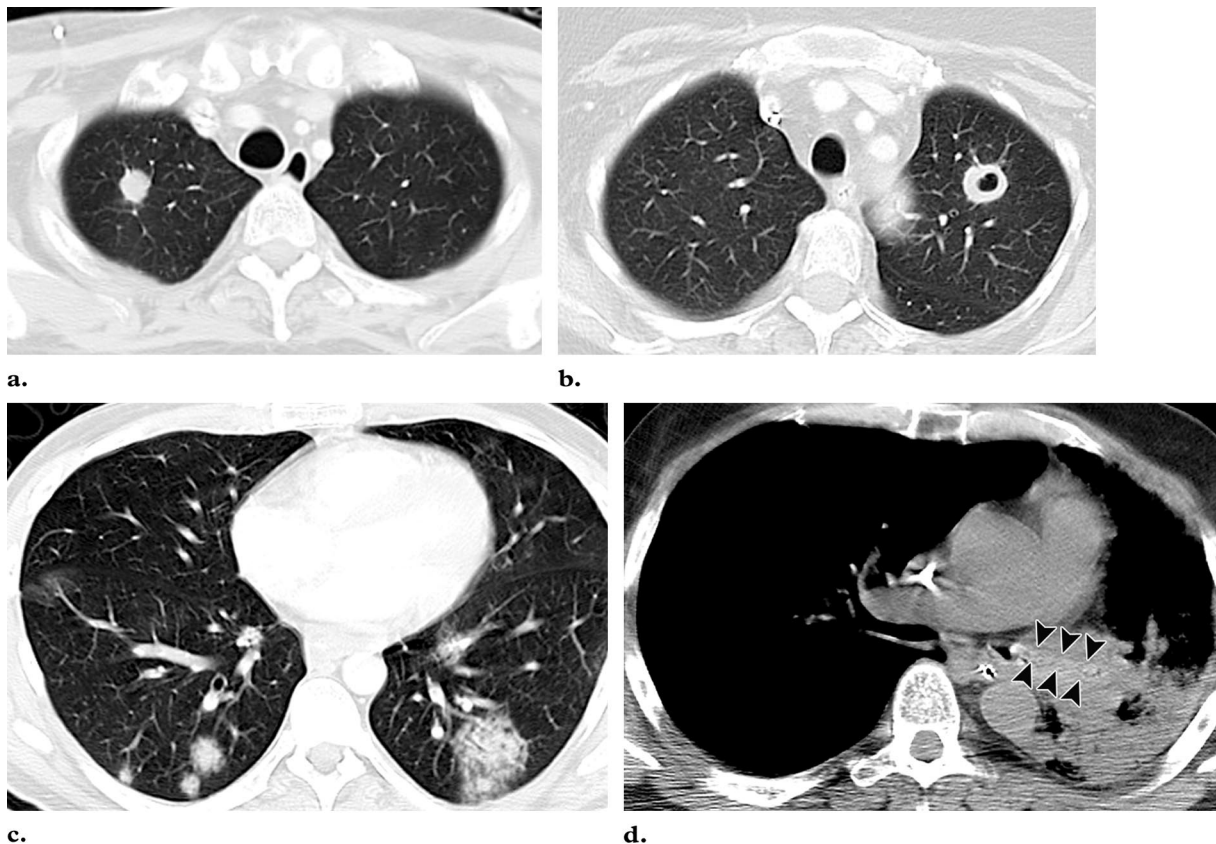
Pulmonary aspergillosis following hematopoietic stem cell transplantation. (a, b) CT scans obtained in two different patients show solitary nodules, with the nodule in b demonstrating cavitation. (c) CT scan obtained in a third patient shows multiple nodules surrounded by a halo of ground-glass attenuation, a finding that indicates hemorrhage resulting from pulmonary infarction. (d) CT scan obtained in a fourth patient shows tracheobronchial aspergillosis with debris filling the left lower lobe bronchus (arrowheads) and consolidation in the left lower lobe.
